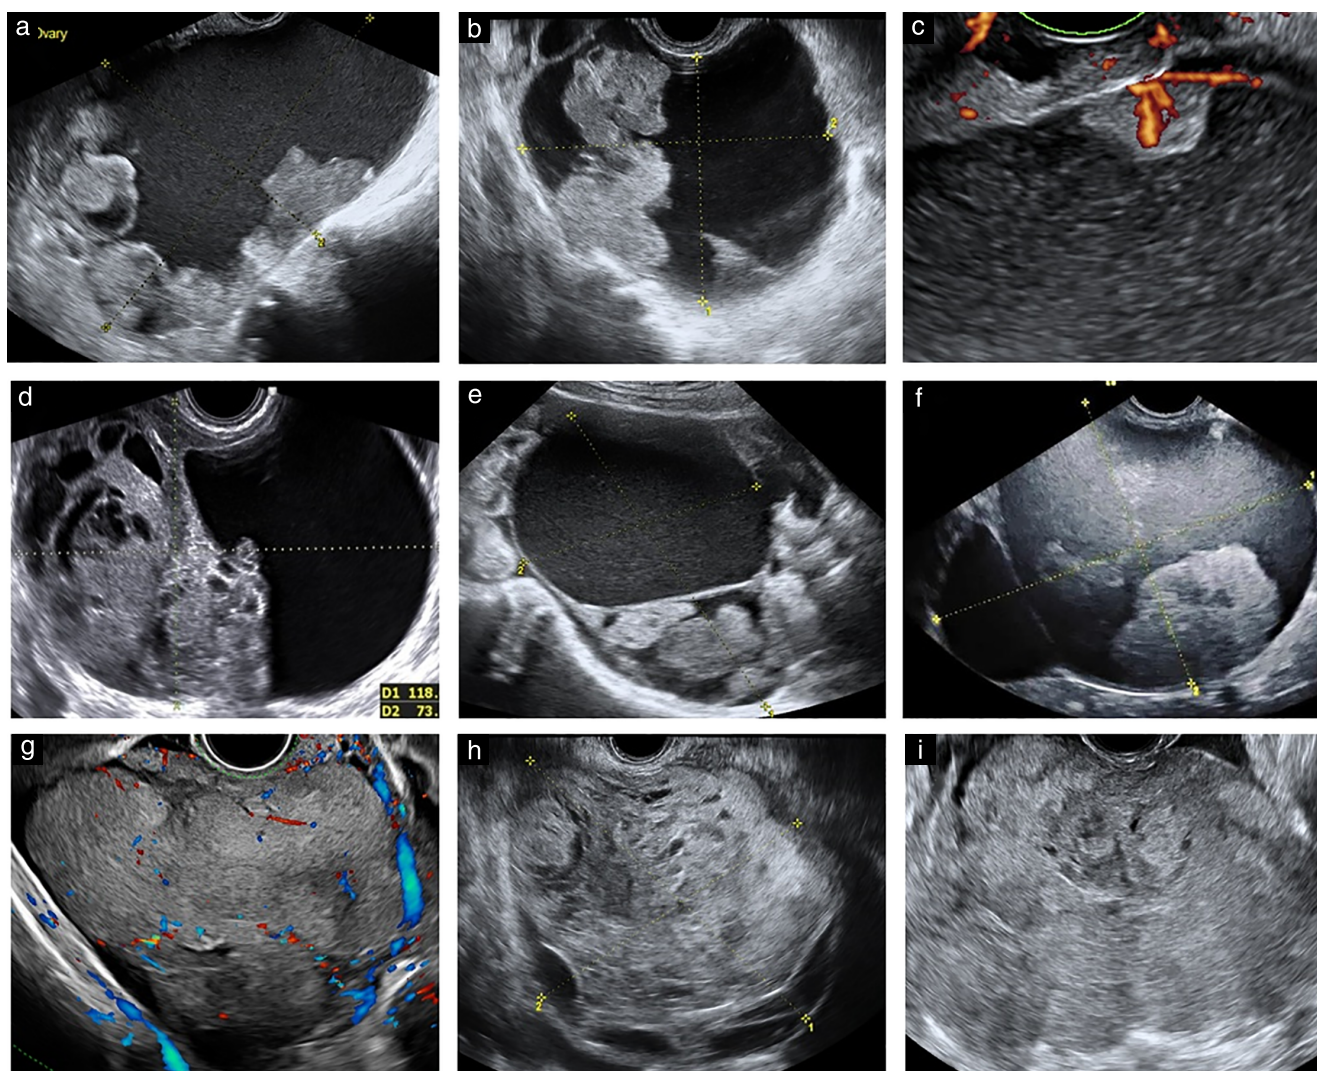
Ultrasound images showing ovarian pure clear cell carcinoma types described by original ultrasound examiner: unilocular-solid cyst (a–c), multilocular-solid cyst (d–f) and solid mass (g–i). Papillary projections were observed in some tumors (a,c,e,f).
